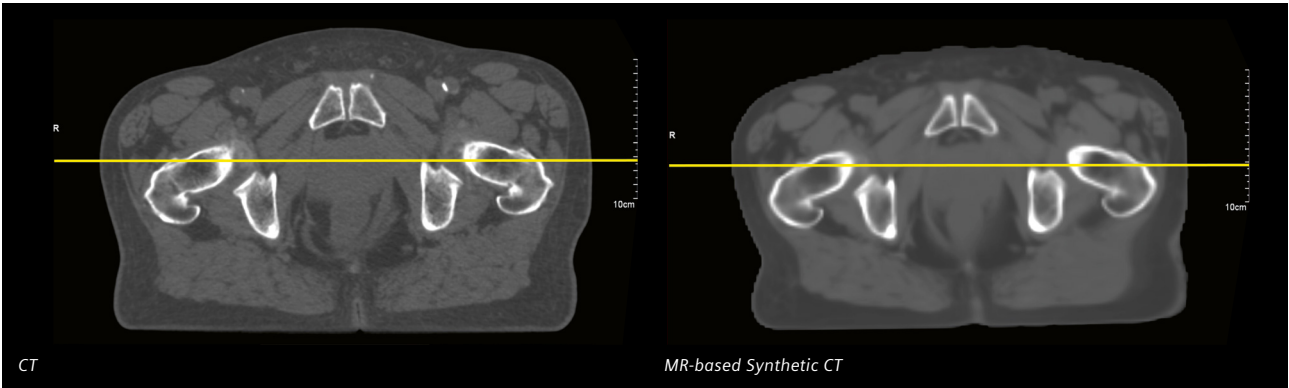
Left image: Planning CT, right image: MR-based Synthetic CT and graph comparing HU along the line profile (yellow lines).
